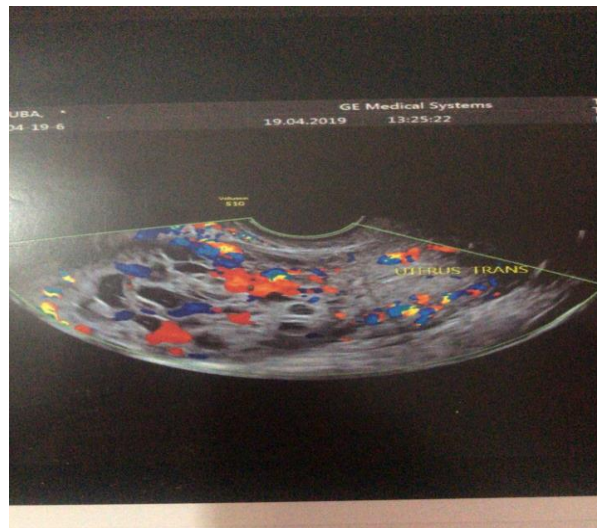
Pelvic ultrasonography that shows an hypervascularized latero-uterine mass with multiples cystic images
